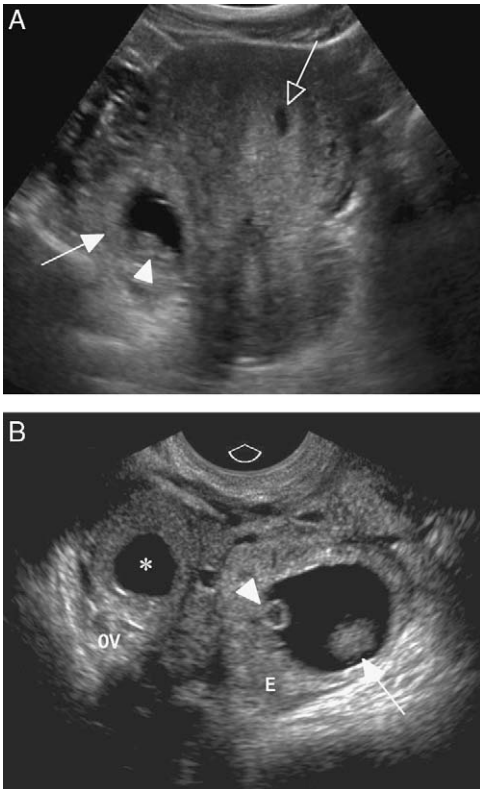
Ectopic pregnancy with a yolk sac and fetal pole. (A) Sagittal transabdominal ultrasound of the uterus shows a small central fluid collection (open arrow), consistent with a pseudosac. A ring-shaped structure (closed arrow) adjacent to the uterus contains a fetal pole (arrowhead), confirming an ectopic pregnancy. (B) Transvaginal ultrasound of the right adnexa in the same patient better demonstrates the ectopic pregnancy (E), with a yolk sac (arrowhead) and fetal pole (arrow), separate from the right ovary (OV), which contains a corpus luteum (*).
